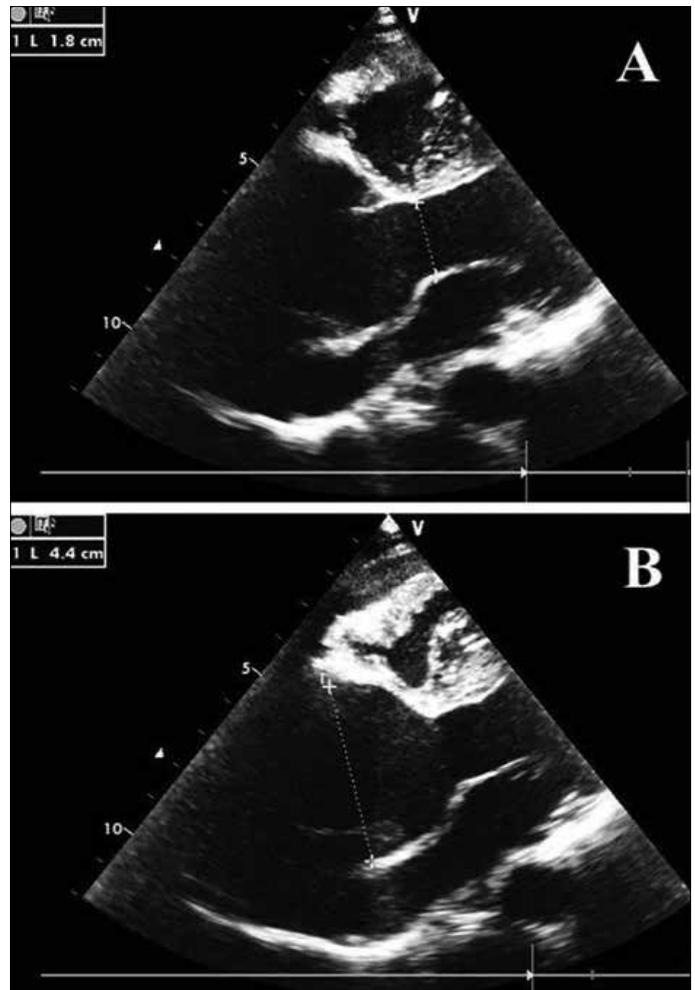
Transthoracic echocardiography demonstrates dilatation of the ascending aorta and pericardial effusion
